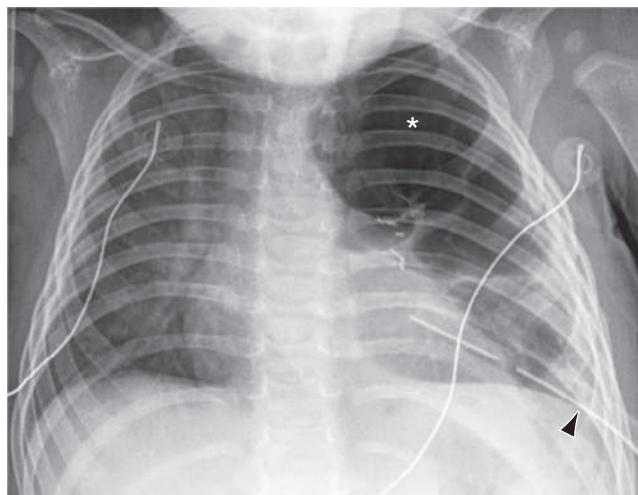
Bronchopleural fistula following surgical resection of the left upper lobe as a result of congenital lobar emphysema. Chest radiograph shows localized pneumothorax (asterisk) that persisted despite prior insertion of a large-bore chest tube (arrowhead).
